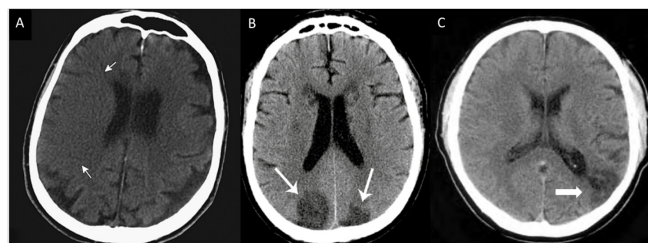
Imagistic findings on brain CT in different stroke phases
